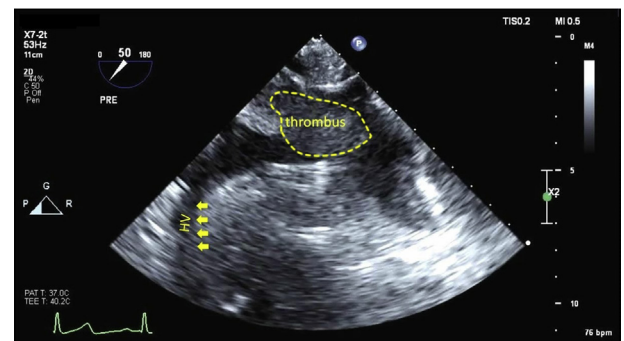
Transesophageal echocardiographic bicaval view with deeper insertion shows the hepatic vein (HV) clear of tumor thrombus. A distinction of echogenicity can be made between the more echogenic proximal end and the less echogenic distal (atrial) end of the mass, with the latter representing bland thrombus (encircled).
